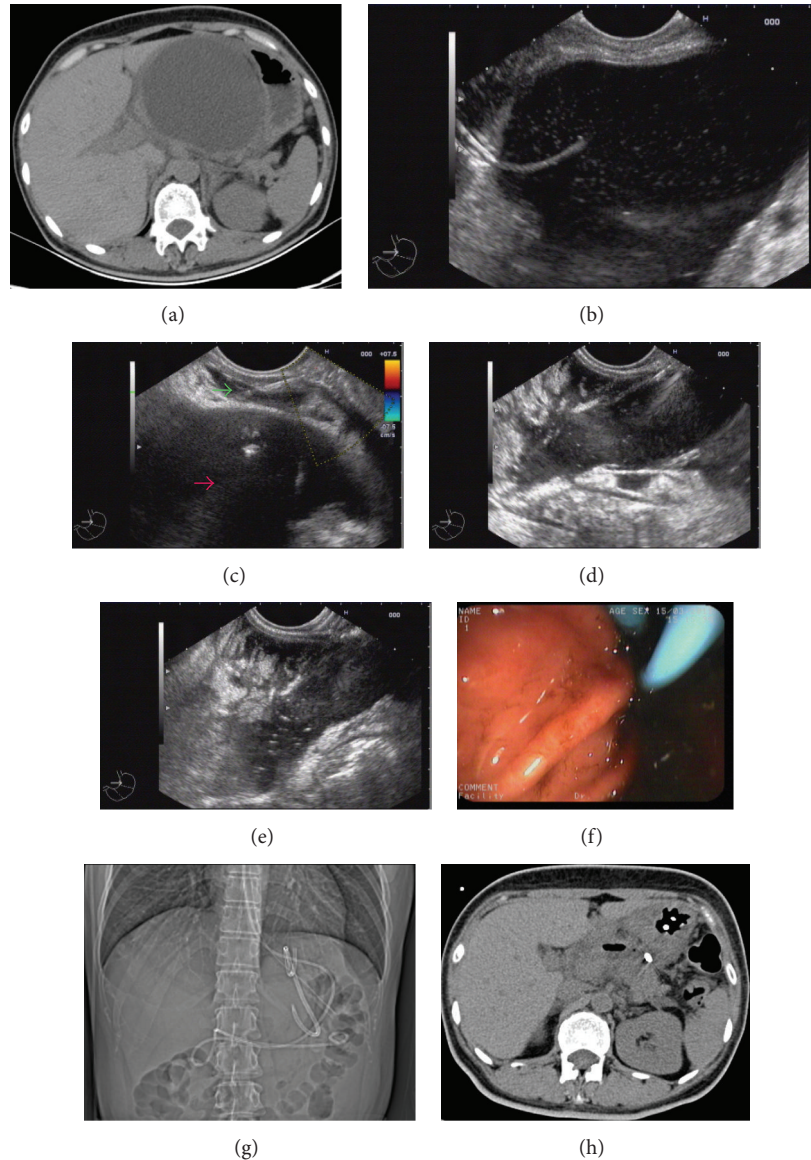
(a) CT shows a large cyst in the upper abdominal area. (b) EUS shows the cyst wall was 3 mm. The wall was not adhered to the gastric wall, as relative movement was observed. (c) After the needle puncture, cyst (red arrow) fluid will leak into the omental bursa. After cystotome dilation and stent placement, fluid leak (green arrow) begins to increase. (d) A large collection of fluid, measuring 3 cm, is seen below the cyst. (e) Transmuram approach by a cystotome. (f) Intraperitoneal drainage by a 7 Fr nasobiliary catheter. (g) Drainage catheters seen on X-ray. (h) Pancreatic pseudocyst size is diminished, as confirmed by CT.
